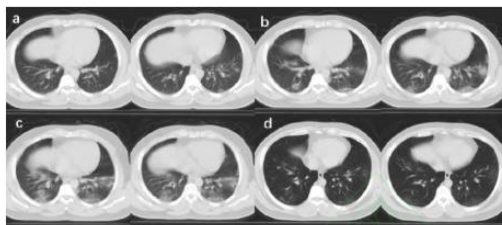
Comparison of chest CT results of patients. (a), chest CT on January 24; (b), chest CT on January 28; (c), chest CT on January 30; (d), chest CT on February 4.
